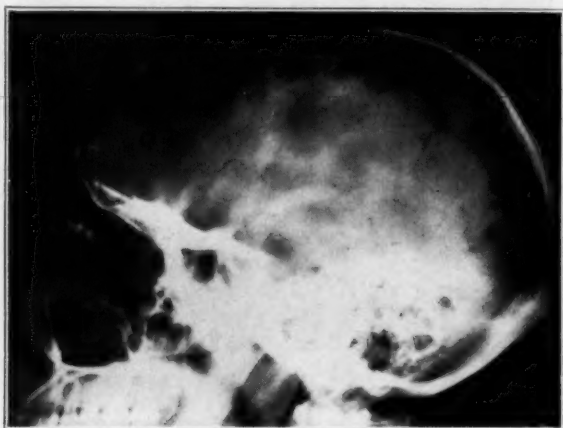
(case 6).—Roentgenogram of the skull, showing an average-sized sella turcica and a hazy dorsum and clinoids suggesting a mild atrophy.
